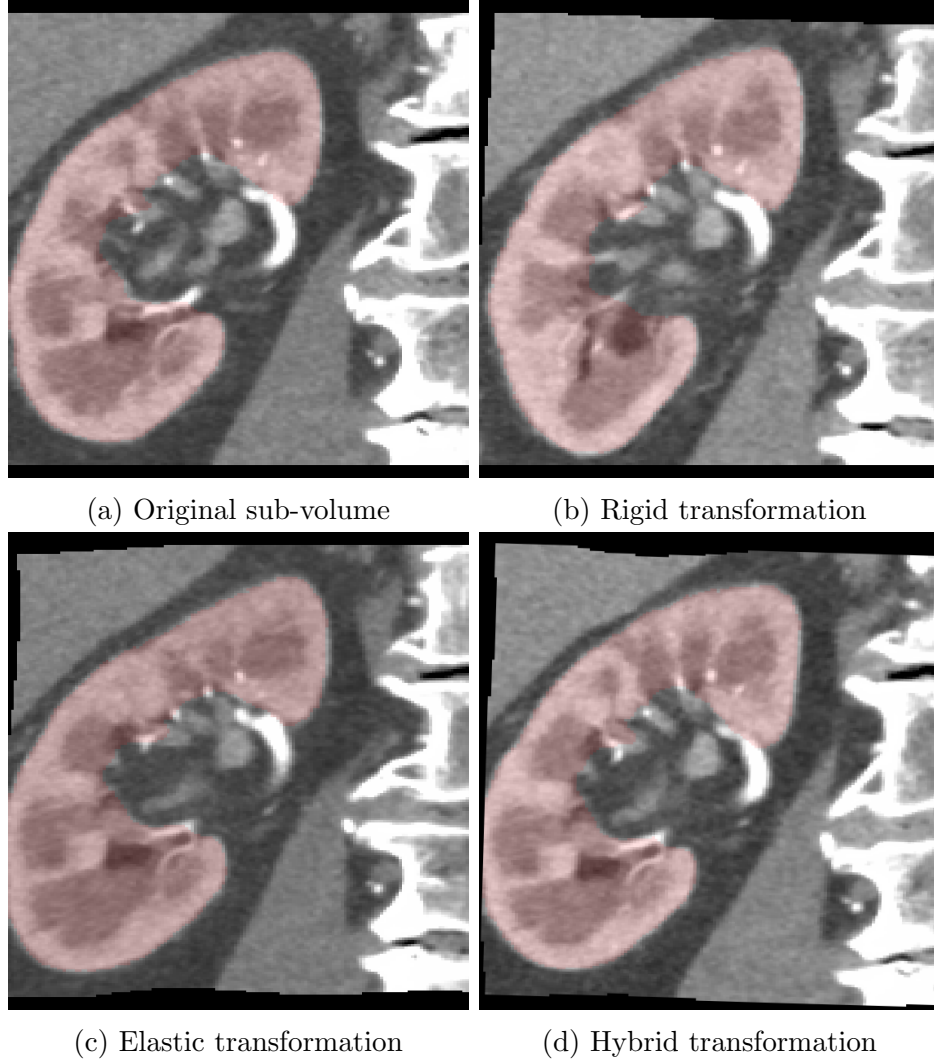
Examples of data augmentation: (a) original sub-volume extracted from CT data. Red region indicates ground-truth label of kidney. (b) and (c) rigid and elastic transformation results. (d) transformation result containing both rigid and elastic transformations
